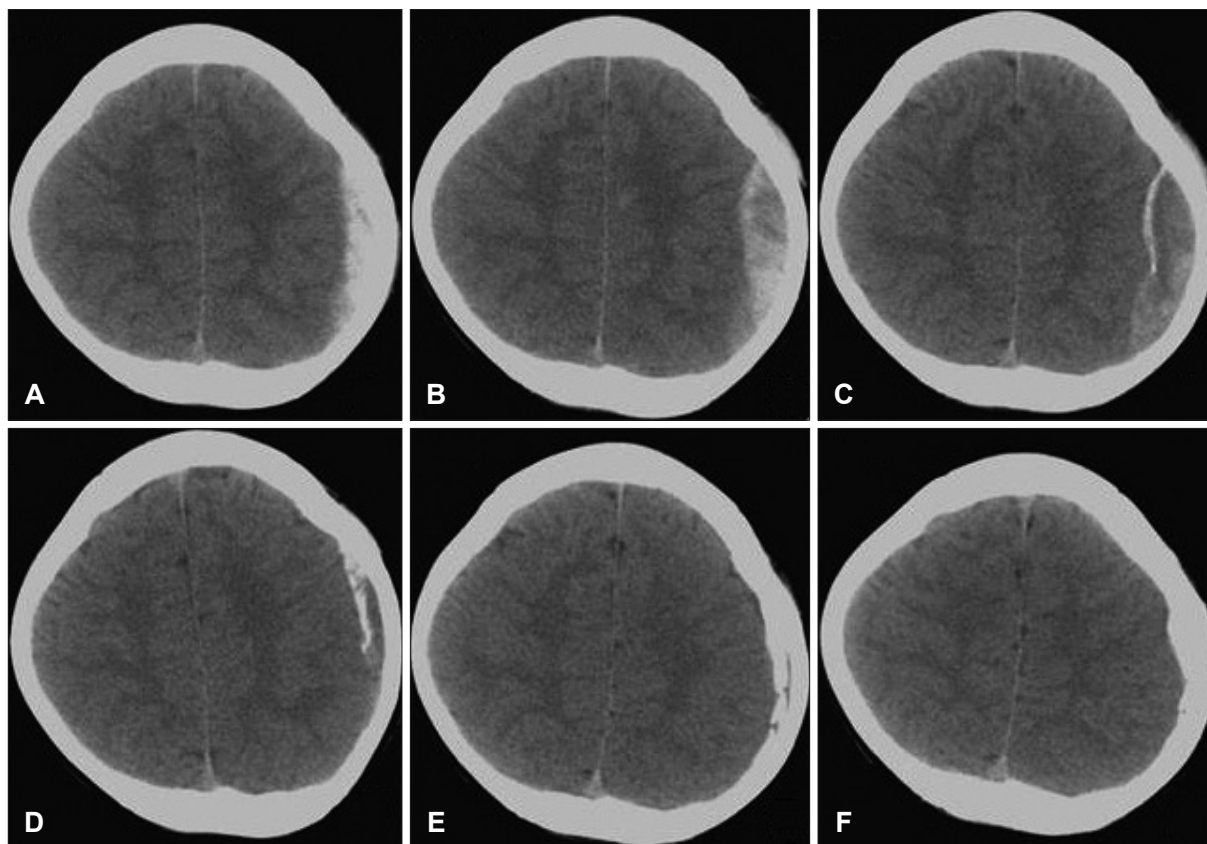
The progressive changes of epidural hematoma (EDH) and calcification on computed tomography (CT) scan. The brain CT on admission reveals left parietal EDH (A). A follow-up CT scan on 1 week later reveals the EDH that is slightly increased in volume (B). Two weeks later, CT scan shows that the EDH size is slightly decreased but a thick layer of calcification is revealed on the dural layer (C). The epidural calcification is growing in thickness of first 2–3 months (D, E). Six month after trauma, follow-up CT shows that the EDH has been fully absorbed, and the calcified lesion merged to inner table of skull (F).
